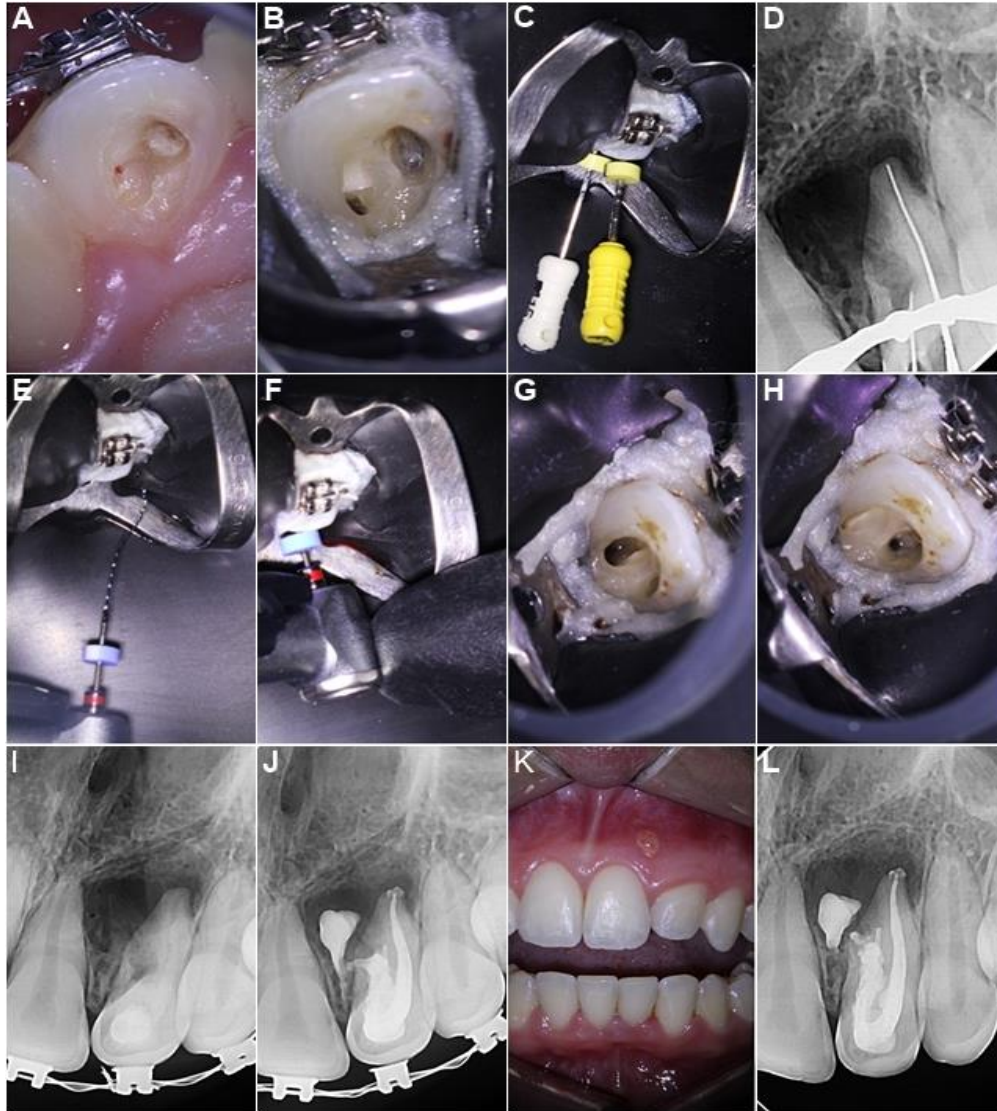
A, B) After performing the access cavity and locating the canals orifices; C, D) Odontometry was performed and checked radiographically; E, F) The XP-Endo Finisher was used to agitate the irrigating solutions; G, H) The canals orifices can be seen after cleaning and shaping; I) The canals were filled with calcium hydroxide and a radiograph was taken to confirm root canals filling; J) In a subsequent session, after the canals were obturated, an immediate post-operative radiograph was made, which revealed a considerable extravasation of the material into the periradicular region of the pseudoforamen; K, L) In the clinical and radiographic follow-up, 2 months later, there was an absence of healing of the fistula and the apical lesion
